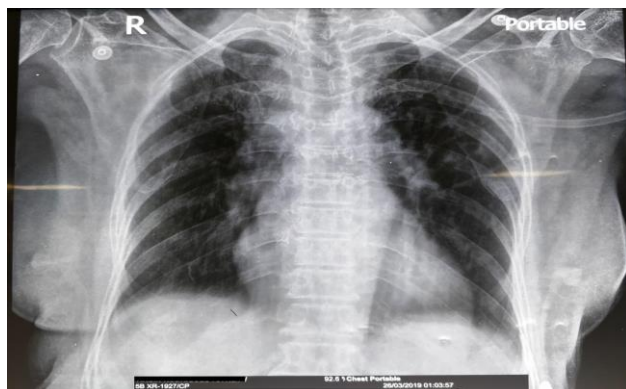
Chest X-ray on 1st day of admission showing peribronchial cuffing
